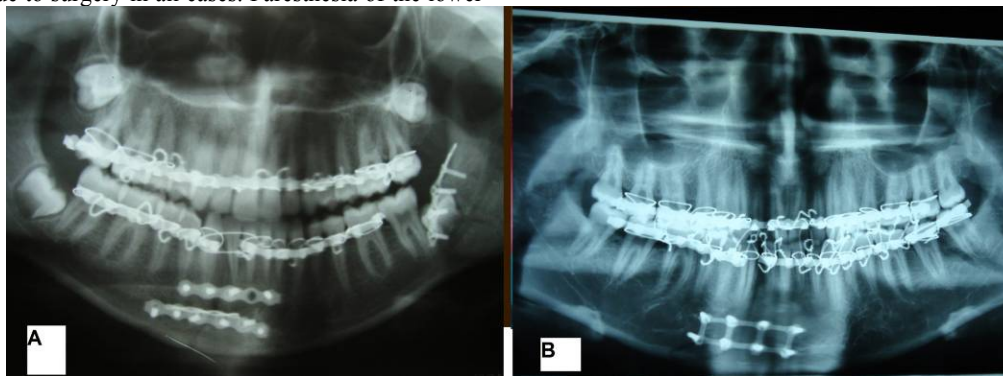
Six months postoperative radiographs A, patients in B, patient in GII
